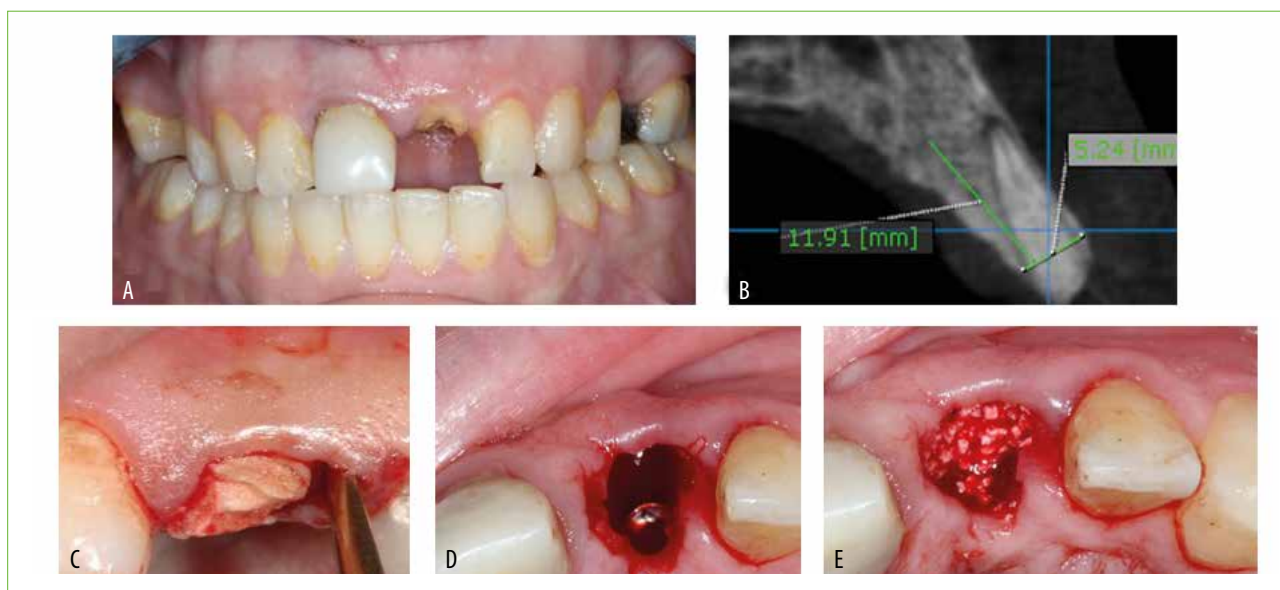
NanoBone grafted jumping gap. Non-restorable upper left 1st central (frontal view) (A), sagittal cut of CBCT showing no dehiscence or fenestration (B), Periosteum was used for atraumatic extraction, (D): Implant placed sub-crestal (C), NB filled the jumping gap (E).
